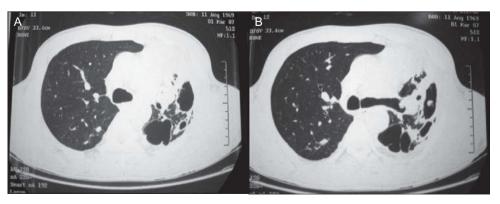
Chest computerized tomography (CT) during hospitalization.
